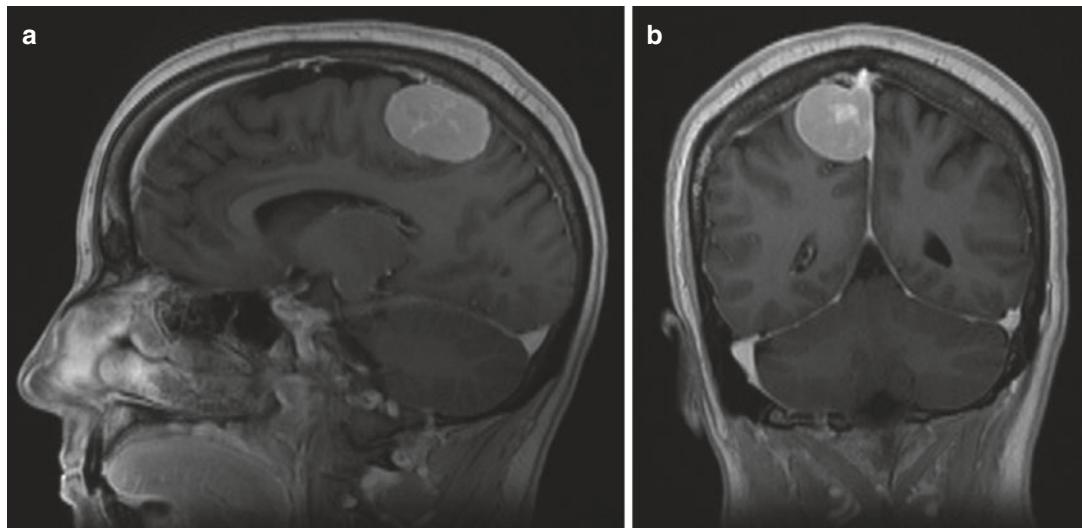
(a) Sagittal and (b) coronal post-contrast T1-weighted MR images showing a convexity meningioma involving the falx and the superior sagittal sinus
